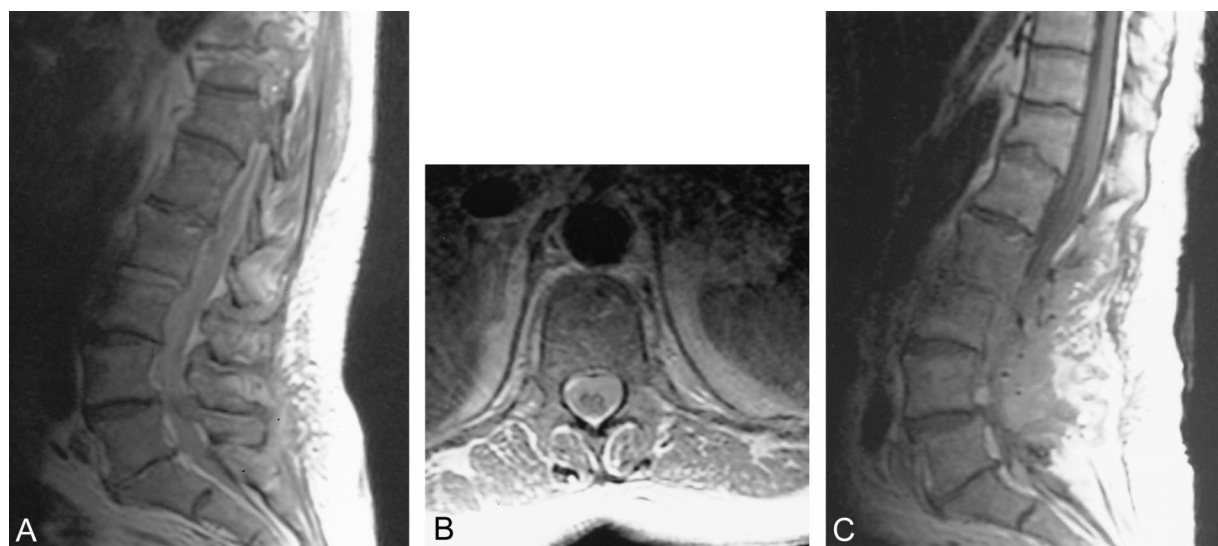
Sagittal (A) 516/12/2 and axial (B) 686/11.6/2 precontrast T1-weighted images of the spine demonstrate diffuse increased signal intensity within the subarachnoid space. Sagittal precontrast T1-weighted (C) 550/12/2 image of the lumbar spine performed 2 weeks later shows resolution of the previously seen increased signal intensity and a normal signal within the CSF. A–C were filmed at the same values for window and level, and were performed on the same scanner.
